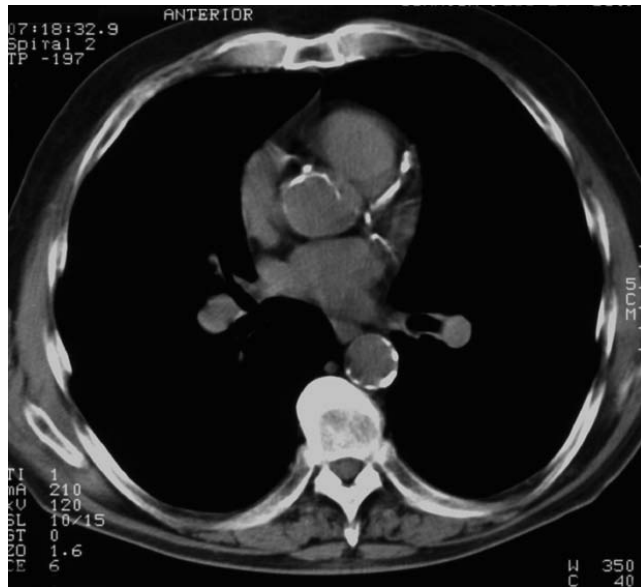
Coronary artery calcification. Heart CT shows dense calcification at the proximal portion of the left anterior descending coronary artery. (Image courtesy of F. Mettler, Jr.)
